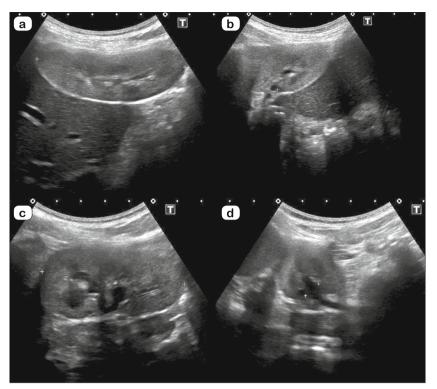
Renal ultrasound. Right kidney (length 61 mm) with altered corticomedullary differentiation – longitudinal view (a). Right kidney – anteroposterior view (b). Left kidney (length 60 mm) with altered corticomedullary differentiation – longitudinal view (c). Left kidney (pelvis width 7.2 mm) –anteroposterior view (d).
